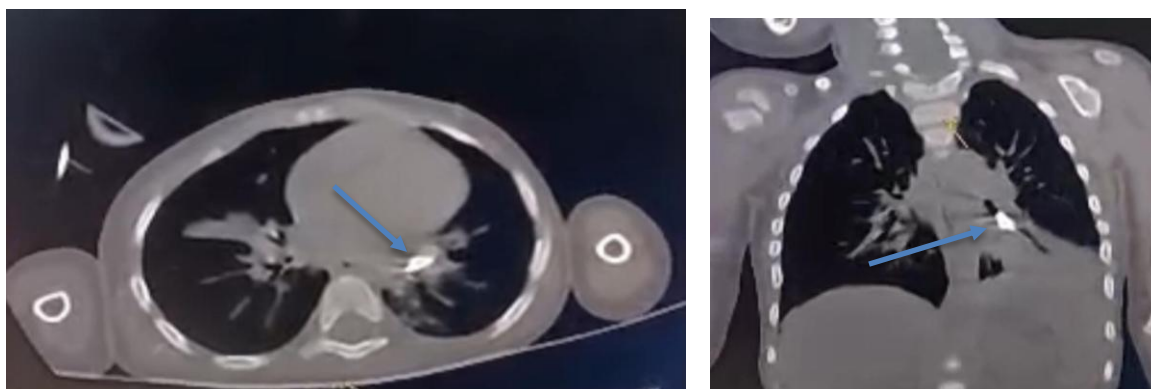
CT chest images showing a radiopaque tooth lodged in the left main bronchus with associated collapse and consolidation of the left lung, confirming obstructive atelectasis.
